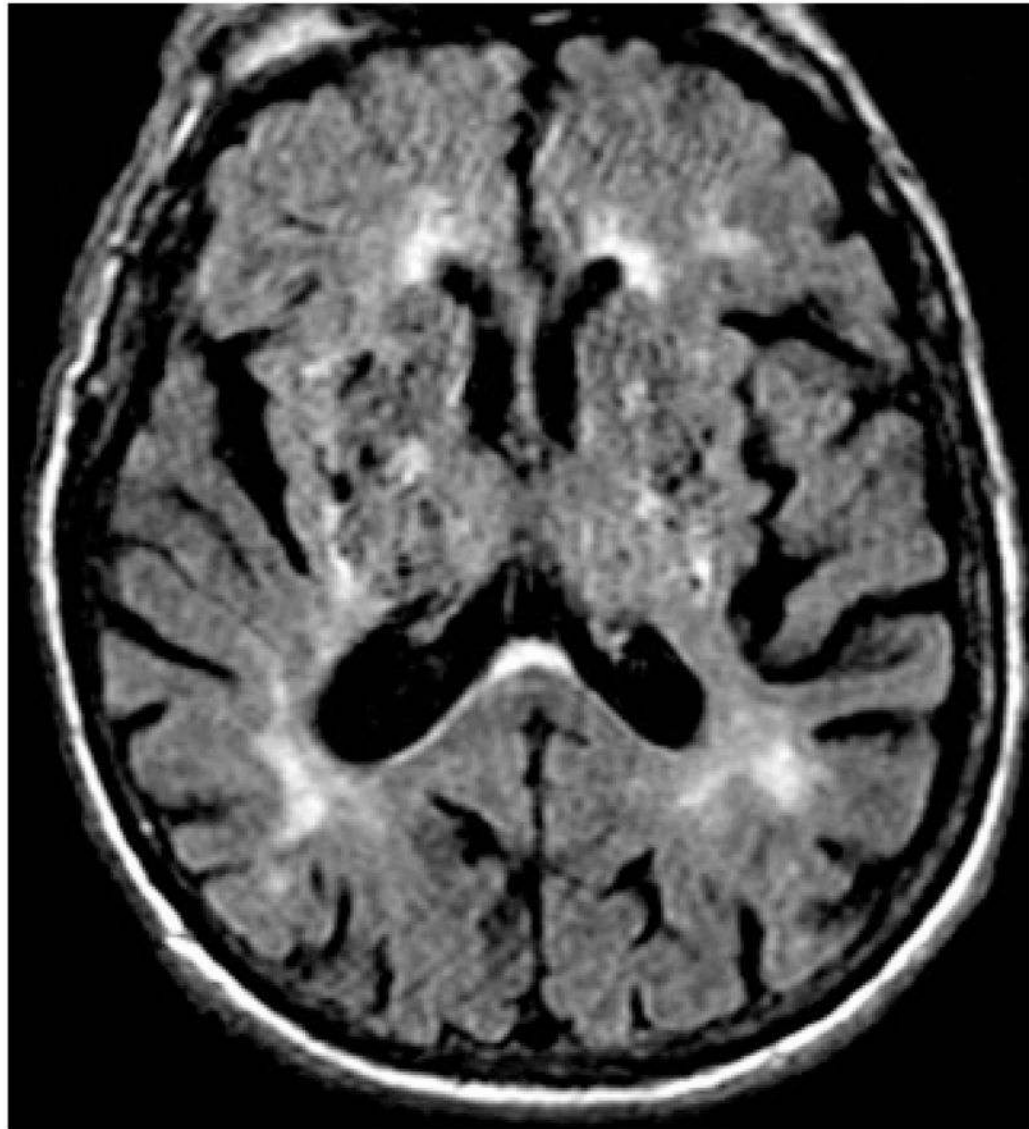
FLAIR MRI of a patient with Binswanger's encephalopathy. Hyperintense signal abnormality is seen at periventricular zones, white matter immediately beneath cortex, splenium of the CC, and internal and external/extreme capsule regions. Multiple hypodensities consistent with lacunar infarcts are also seen in the basal ganglia and thalamus.²
